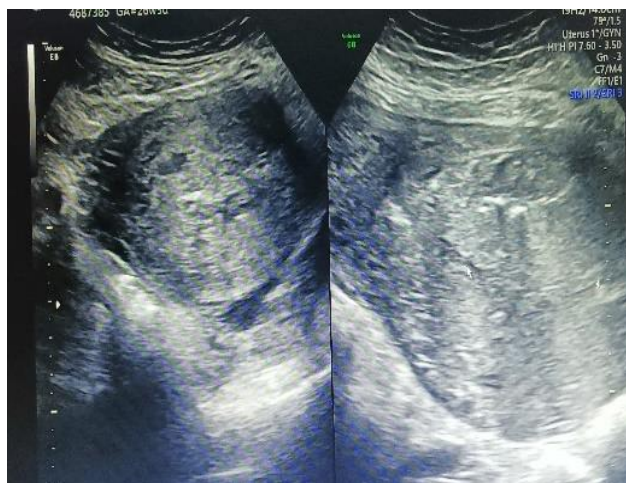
Pelvic ultrasonography performed on postnatal day 1 showing retained placenta.
